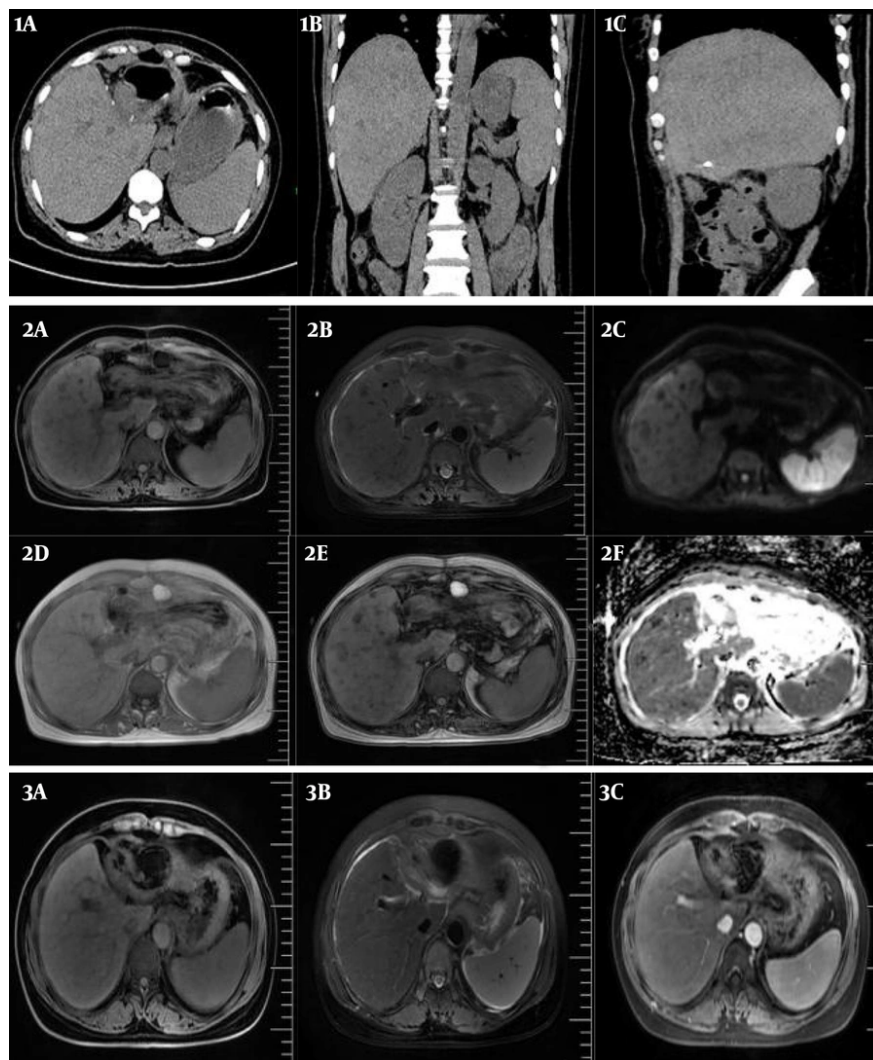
Imaging findings. (1A-1C) Unenhanced computed tomography shows multiple hypodense nodules; (2A) T1-weighted imaging shows hyperintensity; (2B) T2-weighted imaging shows hyperintensity; (2C) diffusion-weighted imaging shows hypointensity; (2D-2E) opposed-phase imaging shows signal reduction consistent with fat; (2F) apparent diffusion coefficient mapping shows no restricted diffusion; and (3A-3C) follow-up magnetic resonance imaging after parenteral nutrition discontinuation shows partial lesion regression.
